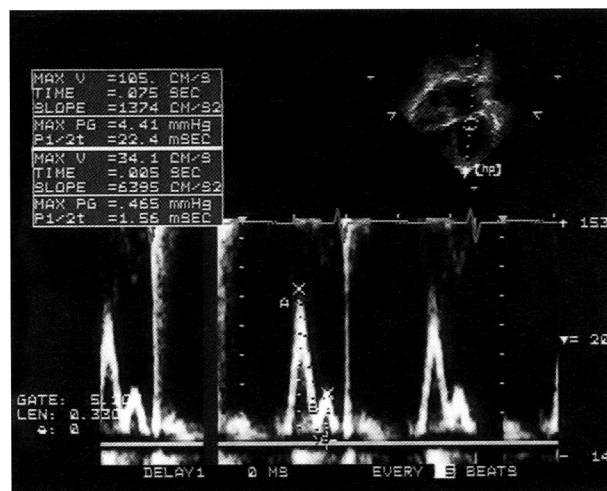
Mitral valve Doppler recording from the patient.
